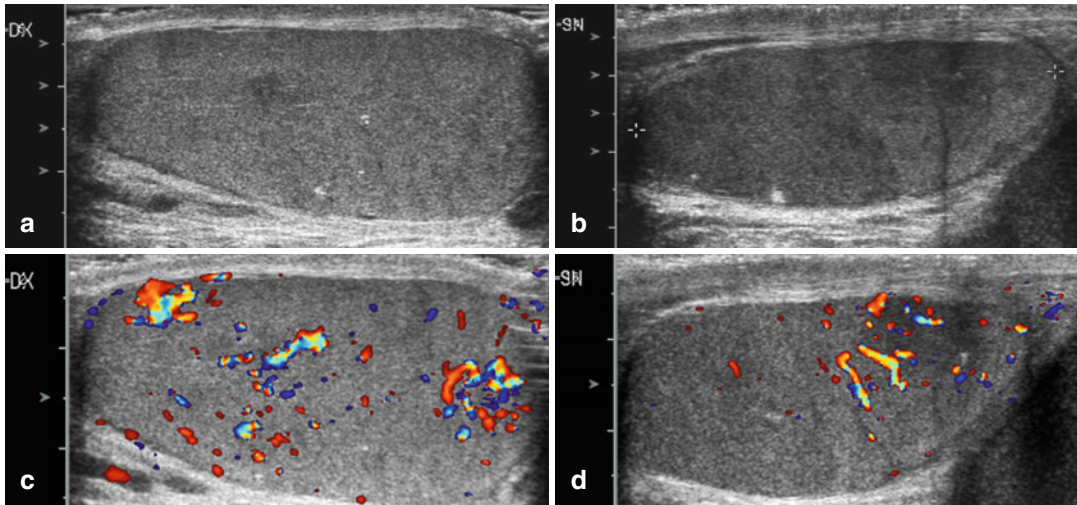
Ultrasound longitudinal scans (A,B) in teenager with pain in the left testicle due to partial left testis torsion. Note the similar echogenicity of the two testicles
